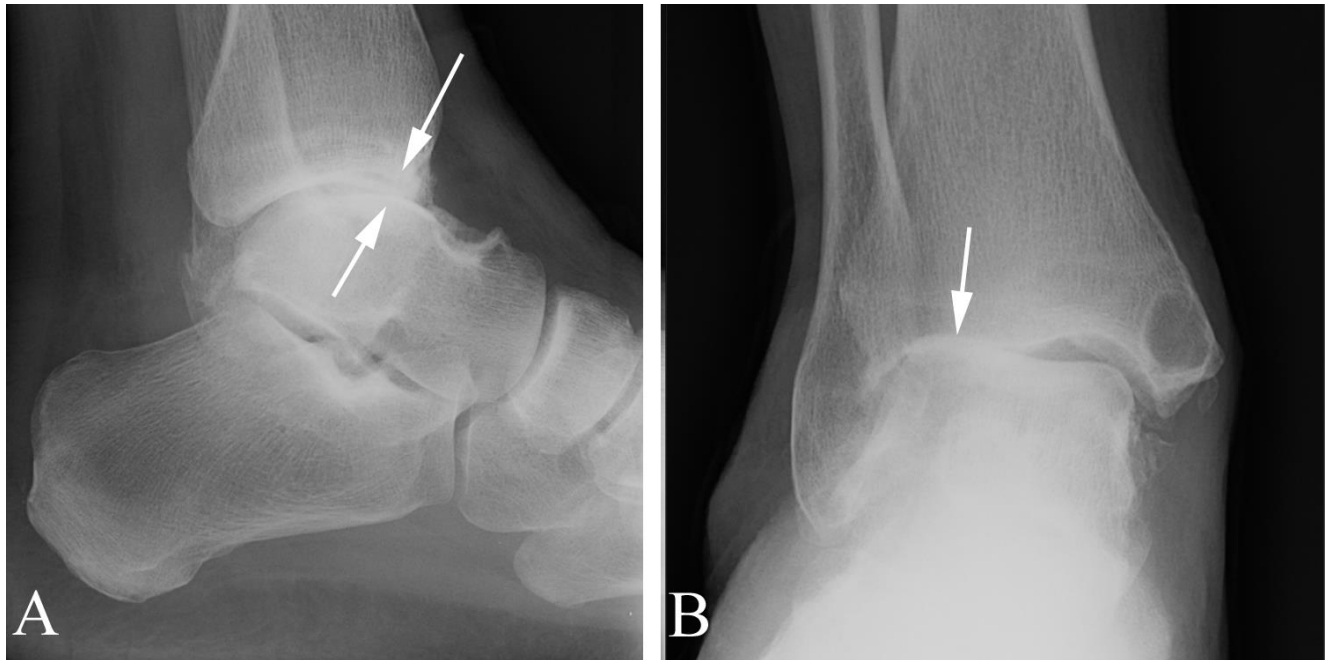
Osteoarthritis of the ankle in a 71 year old man with chronic ankle pain. A. Lateral plain film examination shows joint narrowing (arrows), subchondral sclerosis, and osteophytic spurring along the ankle joint. B. AP plain film also demonstrates joint narrowing, subchondral sclerosis, and osteophytic spurring (arrows). Note the large cyst in the medial malleolus.
